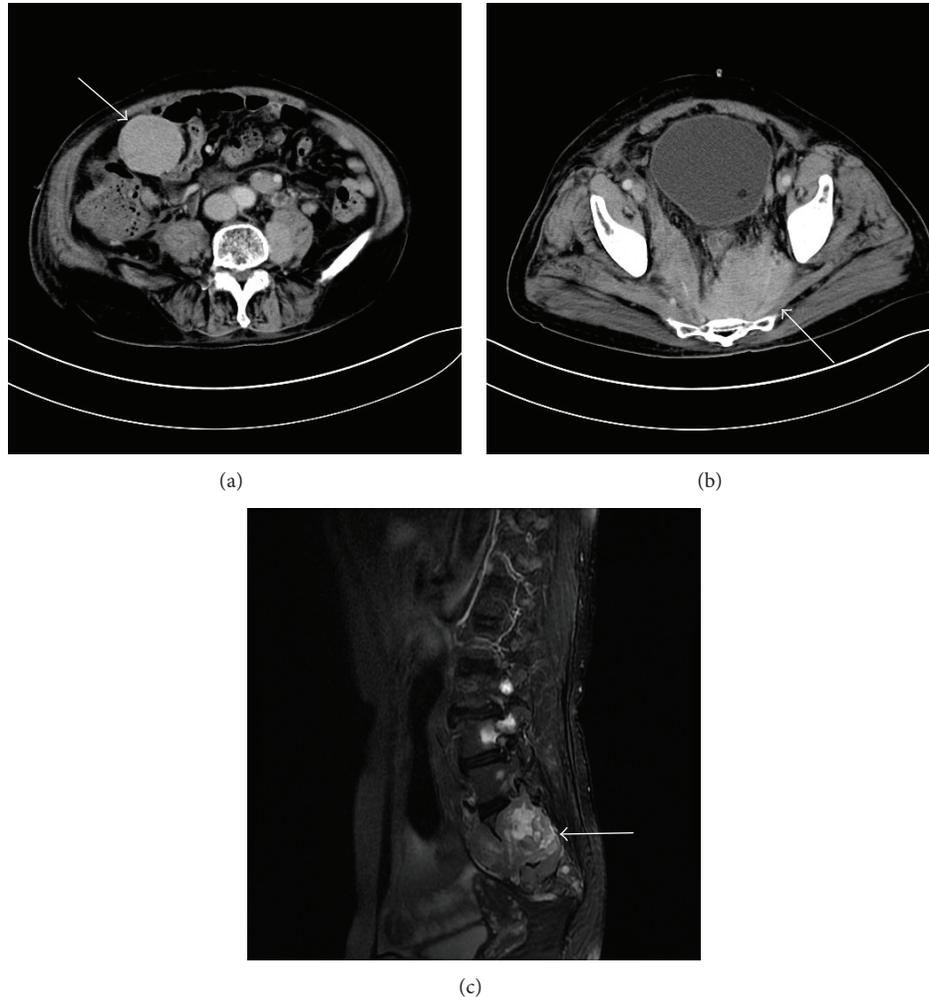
CT/MRI scan images. (a) Enhanced abdominal CT demonstrated soft tissue mass in the right middle abdomen (arrow). (b) Enhanced abdominal CT demonstrated soft tissue mass in the pelvic area (arrow). (c) Fat-suppressed T2-weighted lumbar spine image showed mass (arrow) and the vertebral body and appendix are involved.
